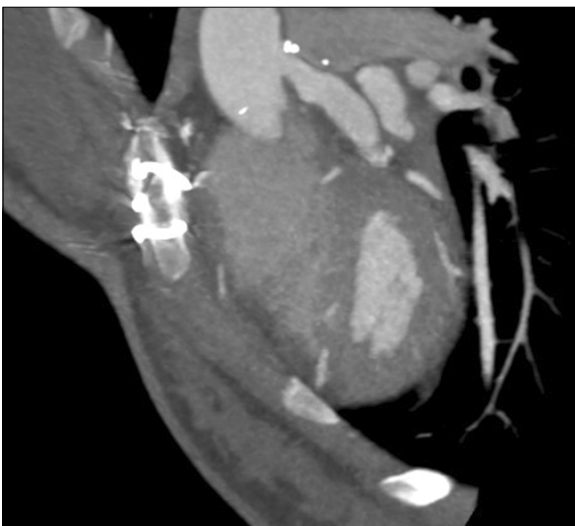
Follow-up computed tomography angiography was performed 5 years after surgery. It showed good coronary patency.
